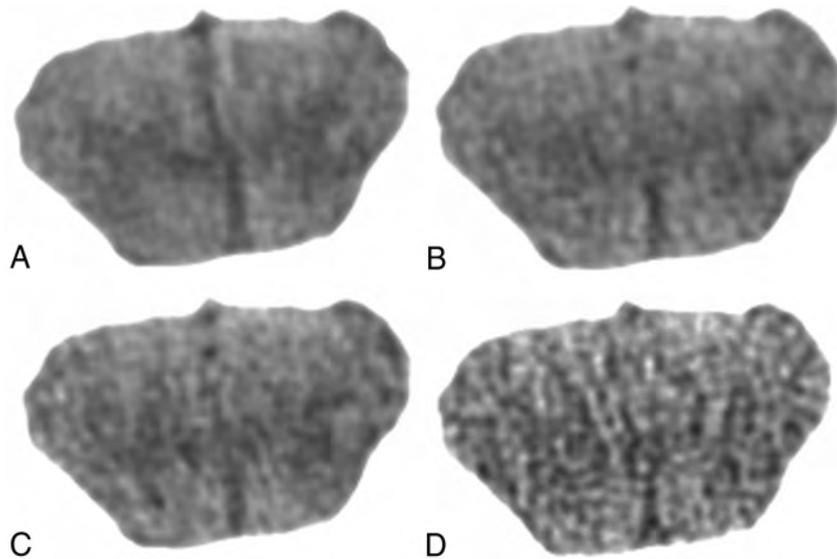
Benchmark coronal head CT images for rating scales of gray-white differentiation: 982 mAs with FBP for score = 4 (A), 573 mAs with FBP for score = 3 (B), 327 mAs with FBP for score = 2 (C), and 82 mAs with FBP for score = 1 (D).
